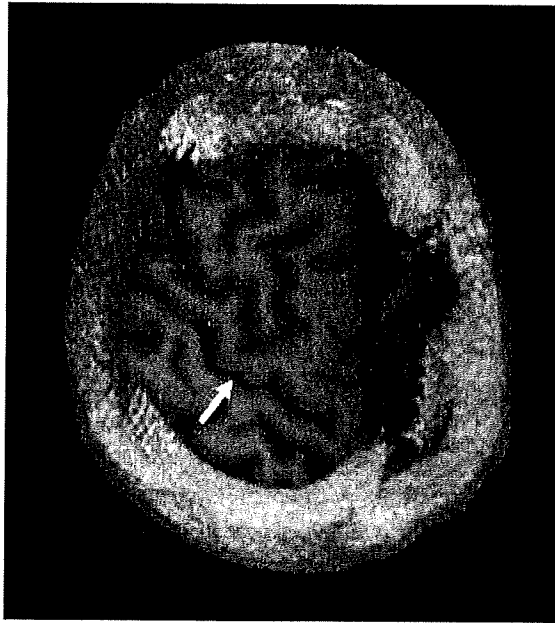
Reconstructed oblique MRI view of the central sulcus (arrow: central sulcus).
